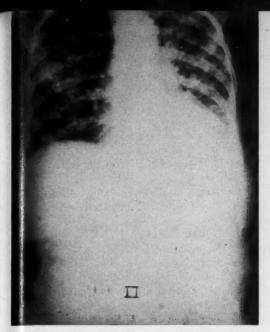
Chest x-ray taken six days prior to death.
